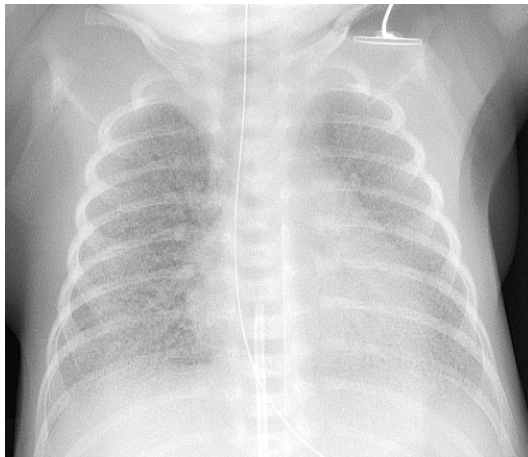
Respiratory Distress Syndrome (RDS) This is a chest x-ray of an infant with classic ground glass or hazy appearance of lungs affected by RDS. The lungs should be black rather than light gray. (credit: “X-ray of infant respiratory distress syndrome (IRDS)” by Mikael Häggström, M.D./Wikimedia Commons, CCO)
